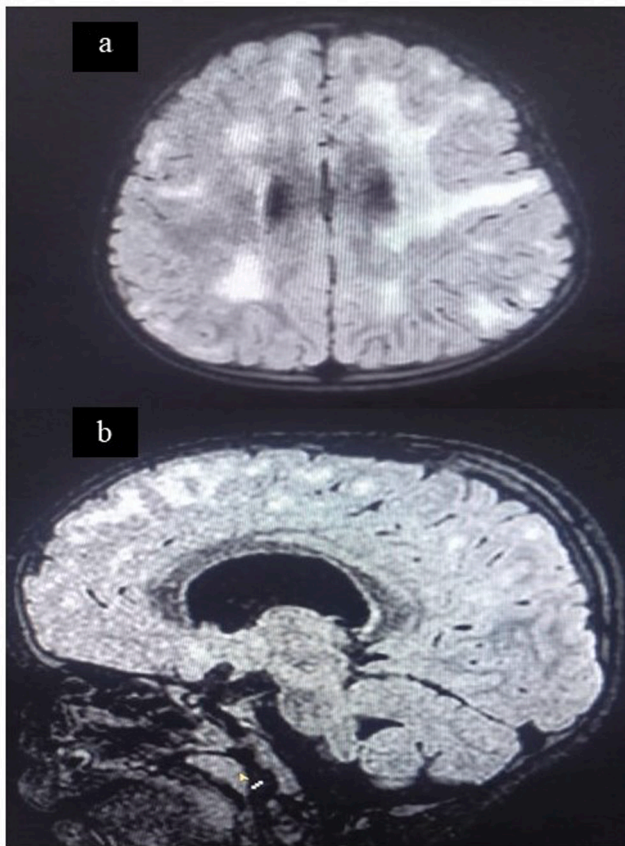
MRI Brain Flair axial (2a) and sagittal (2b) images of case 4 showing asymmetrical, patchy involvement of SC, deep, and PV WM along with CC involvement.
